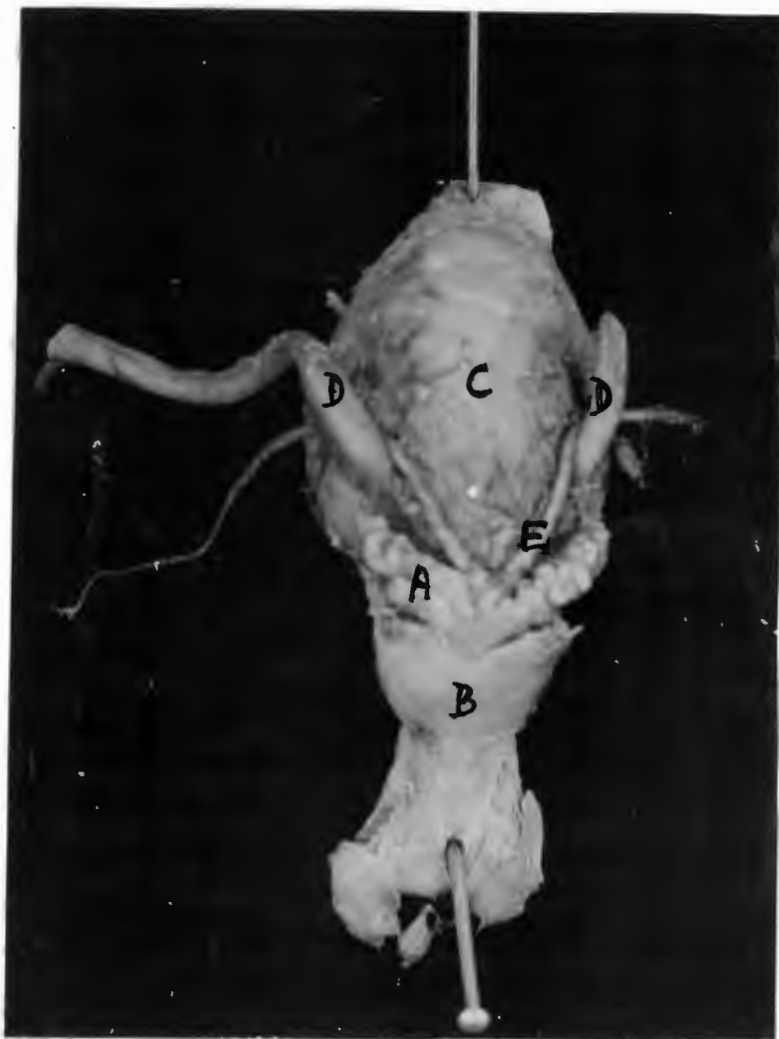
PHOTOGRAPH OF DORSAL ASPECT OF BLADDER AND PROSTATE OF FULL-TERM HUMAN FOETUS.
